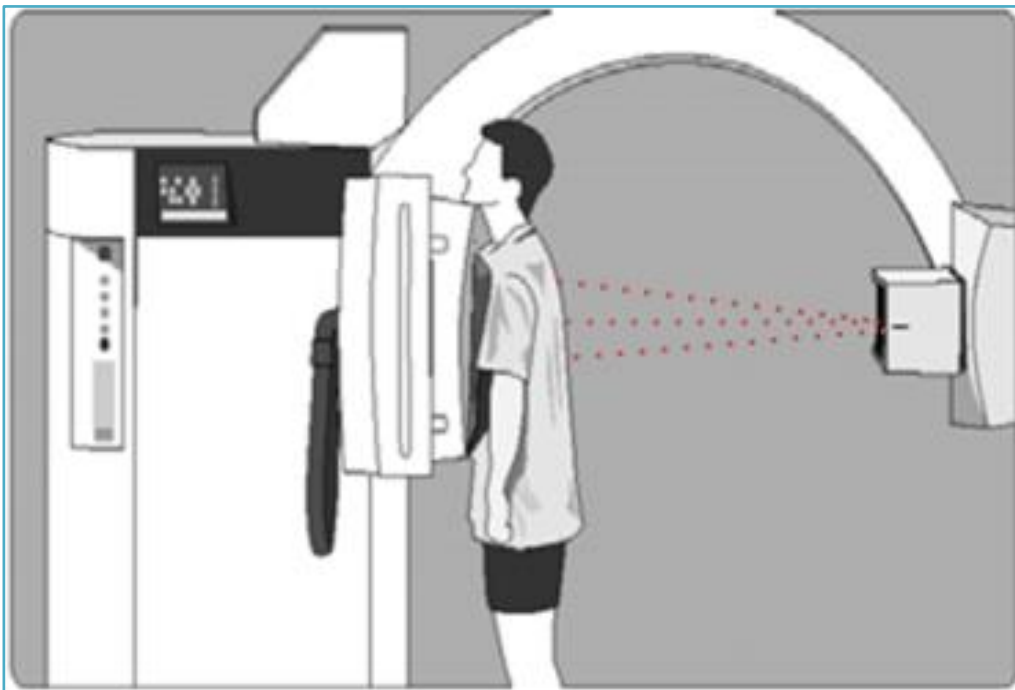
Positioning of X-Ray machine and patient[29].
